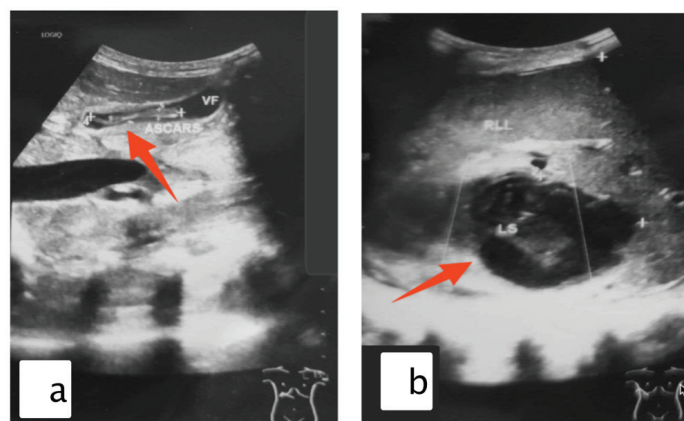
(a) Ultrasonography Showing Worms Within The Gallbladder (b) Ultrasonography Showing A Liver Abscess
